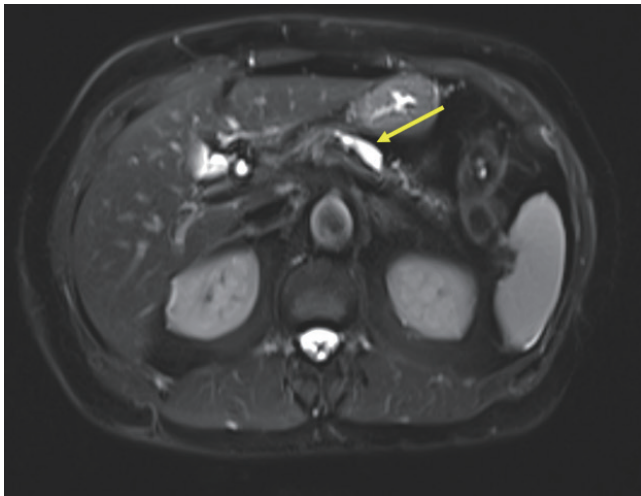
Axial T2 weighted MRI of a 69-year-old female displays a focally dilated main pancreatic duct in the body/tail measuring 8 mm (arrow). The patient underwent distal pancreatectomy and splenectomy, and pathology is consistent with mixed-type intraductal papillary mucinous neoplasm.
